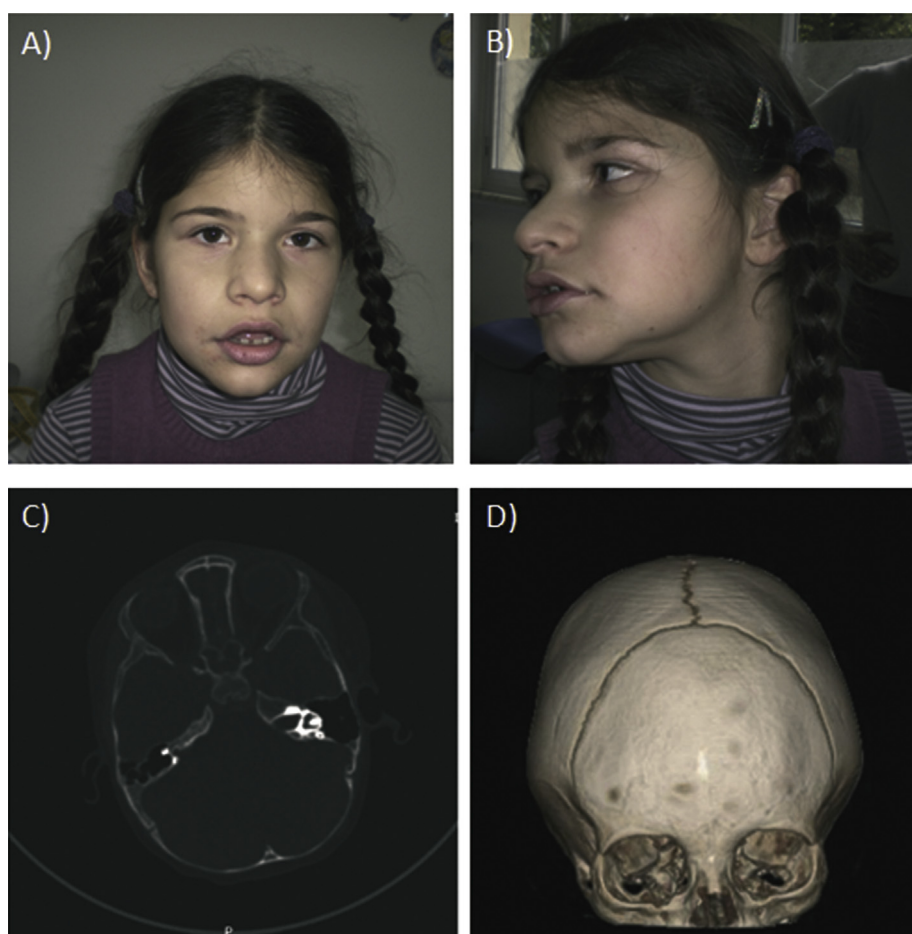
Clinico–radiological features of patients 1 and 2. A–B) Clinical features of patient 1 with horizontal eyebrows, deep set eyes, long nose with broad nasal base, wide mouth held open with thick and everted lips, prominent chin, and hyperplastic helix of both ears. C) CT scan shows synostosis of the metopic suture with decreased interorbital distance in patient 2. D) The 3D Reformation of patient 2 gives the qualitatively clear impression of this dysmorphology: ossification of the metopic suture and medial orbital rim protrusion, led back of the lateral orbital rims and narrowed bitemporal width.
